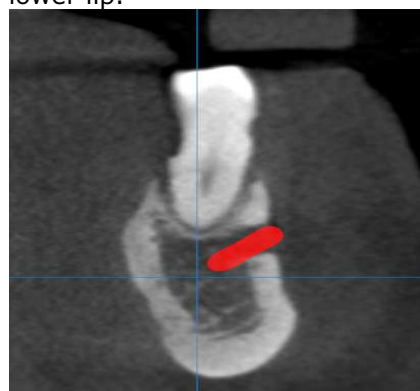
mental nerve as it exits from mental foramen (CBCT).
